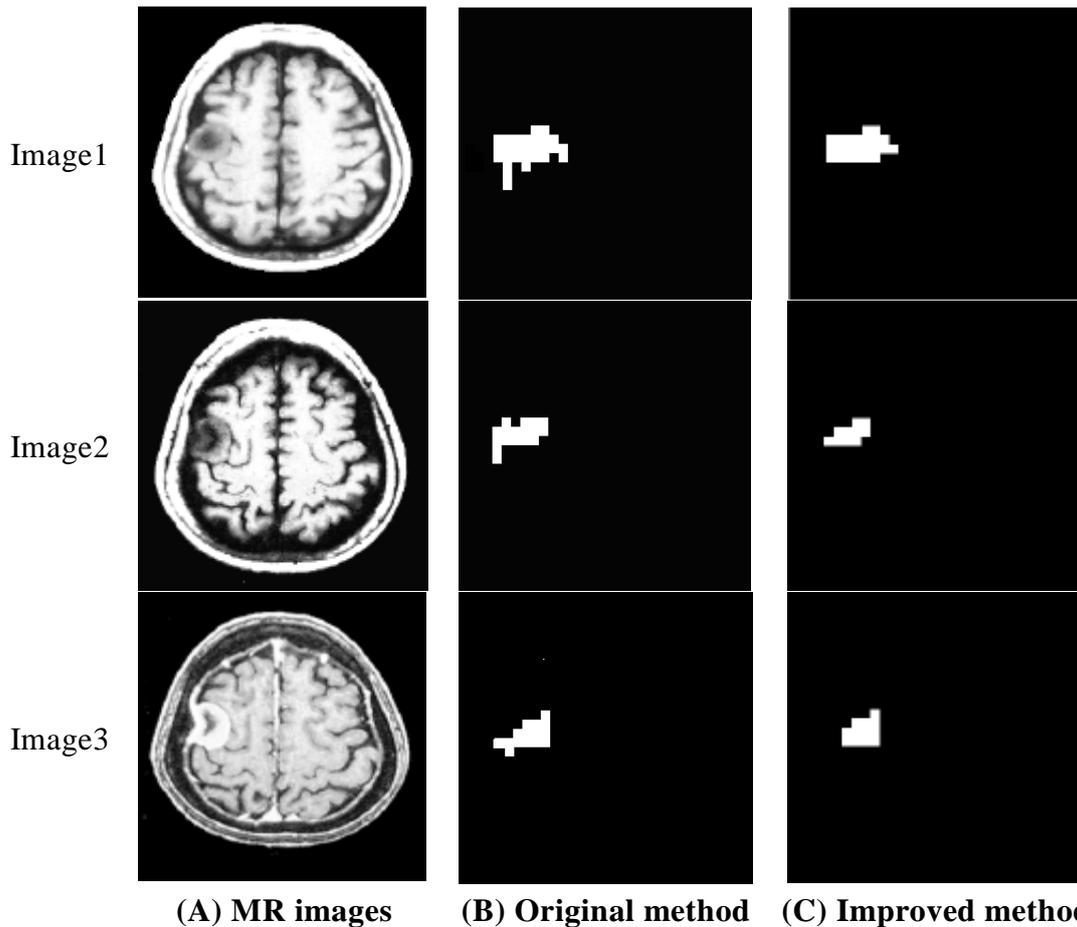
A comparison between the original and improved method for detecting and locating of brain abnormality in three different MR images.
